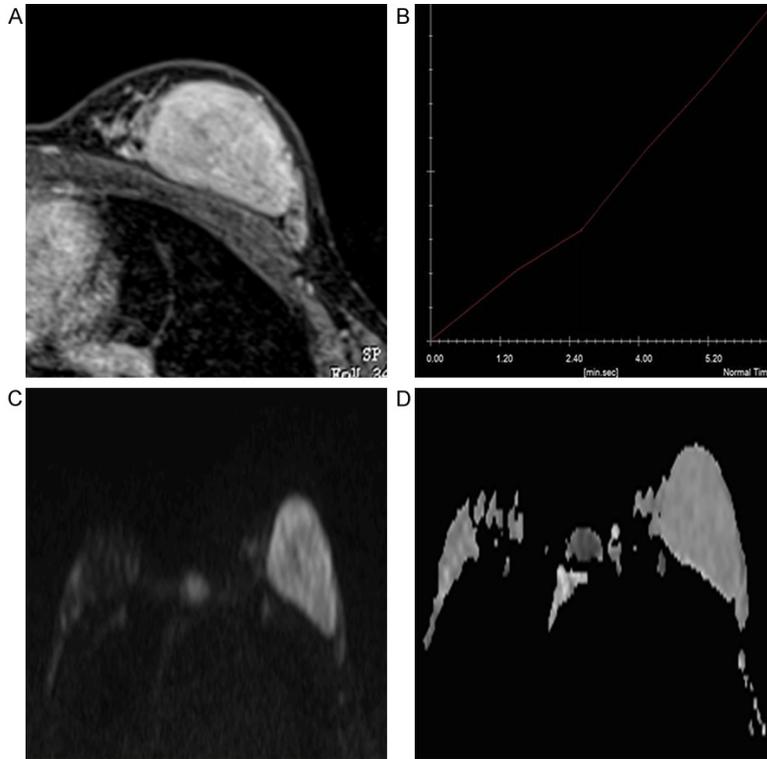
MRI findings for a 39-year-old woman with breast fibroadenoma in the left breast. A. The lesion showed an oval shape with heterogeneous enhancement, smooth margin and constant sharpness sign. B. The time-intensity curve showed a plateau pattern. C. The lesion margin showed high signal in the diffusion-weighted image. D. The lesion margin showed isointensity in the apparent diffusion coefficient map; the coefficient was $1.971 \times 10^{-3} \text{ mm}^2/\text{s}$. The identification value of the lesion was -4.038.
